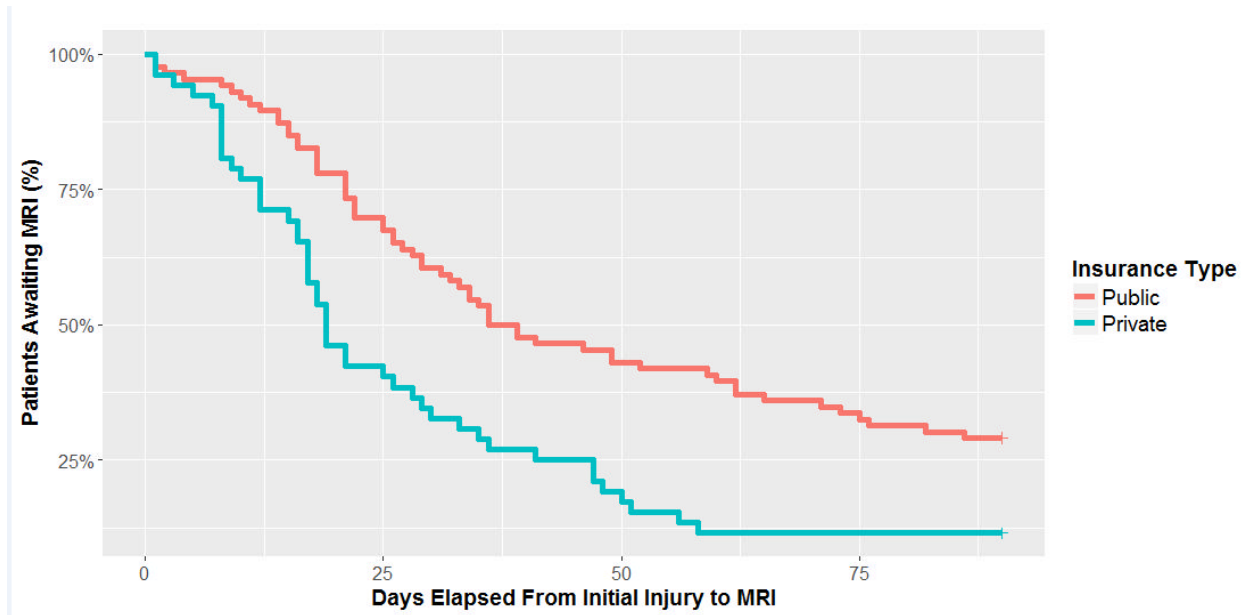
Time from Injury to MRI Stratified by Insurance Type
